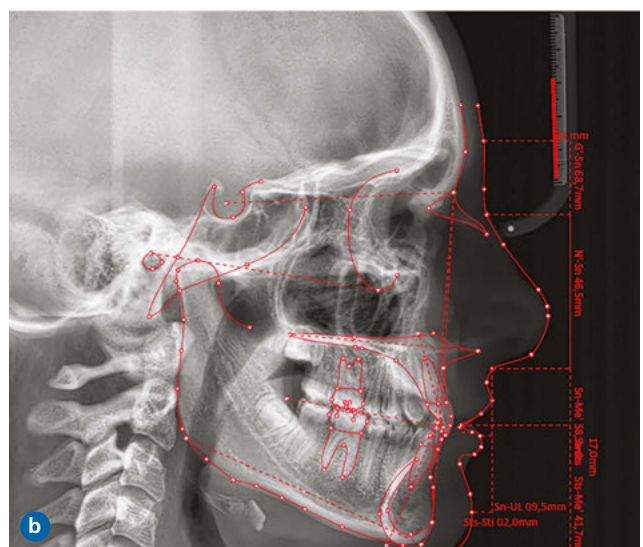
12B Post-treatment x-ray records.
